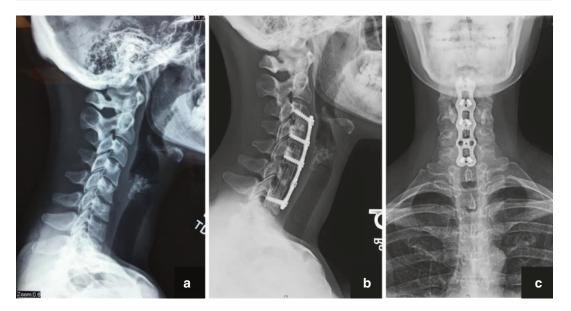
Case presentation: upright cervical x-rays demonstrate a kyphotic cervical alignment (a), which, along with the ventral offending pathology in this case, favors an anterior approach. Cervical reconstruction was
